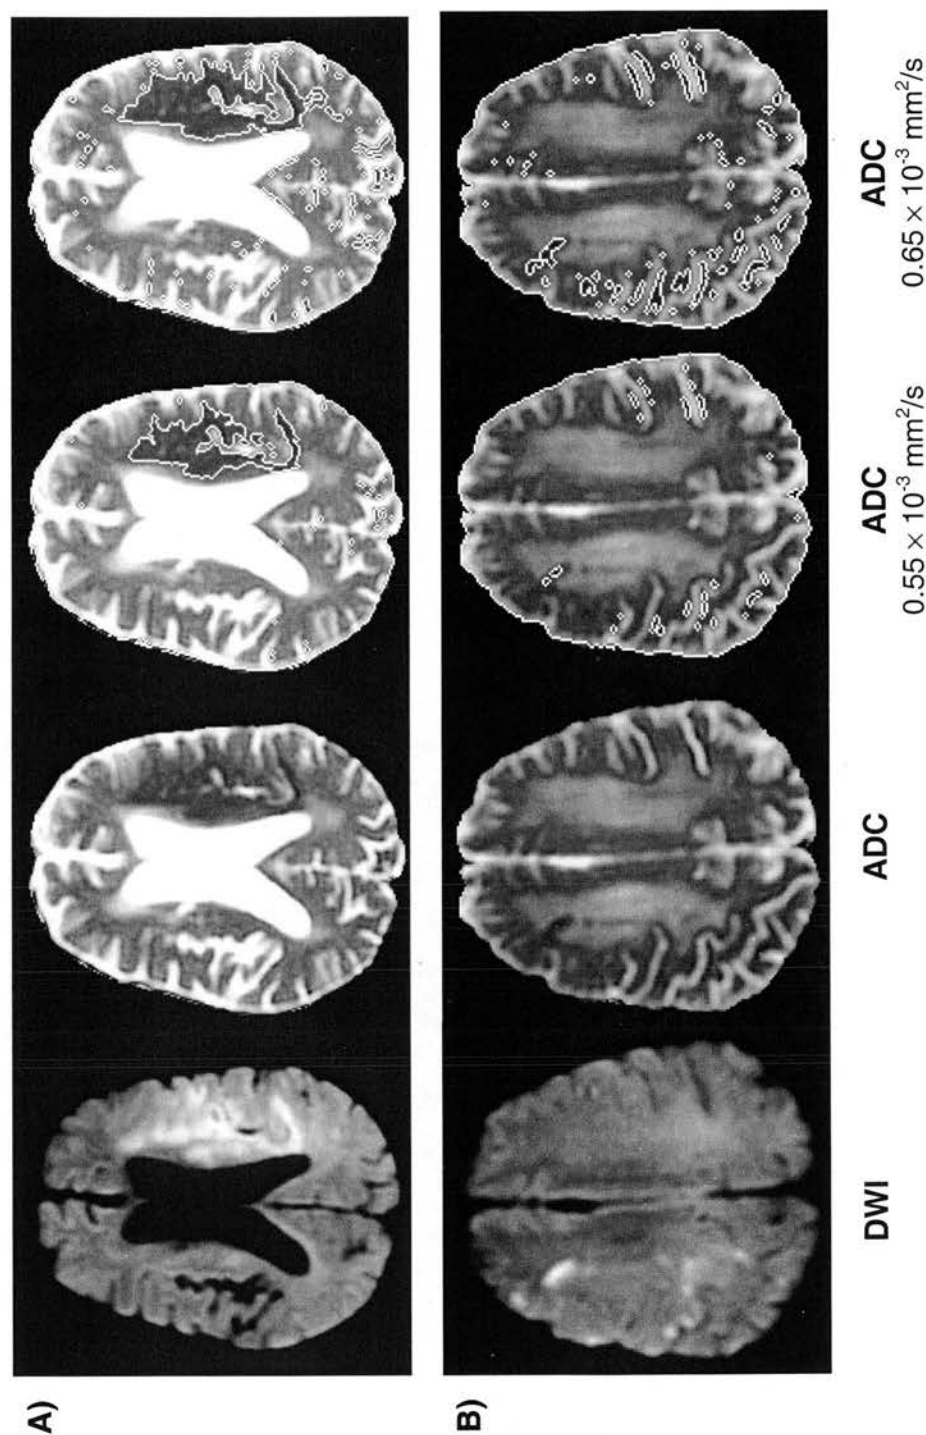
Examples of ADC threshold application in two exemplar patients. A) a patient with a left hemisphere ischaemic lesion (solitary and ill-defined on DWI) at 2 hours after stroke onset; B) a patient with a right hemisphere ischaemic lesion (multi-focal and ill-defined on DWI) at 7 hours after stroke onset. Note the ADC thresholds underestimate lesion extent on DWI and ADC, but include several areas of normal brain.
